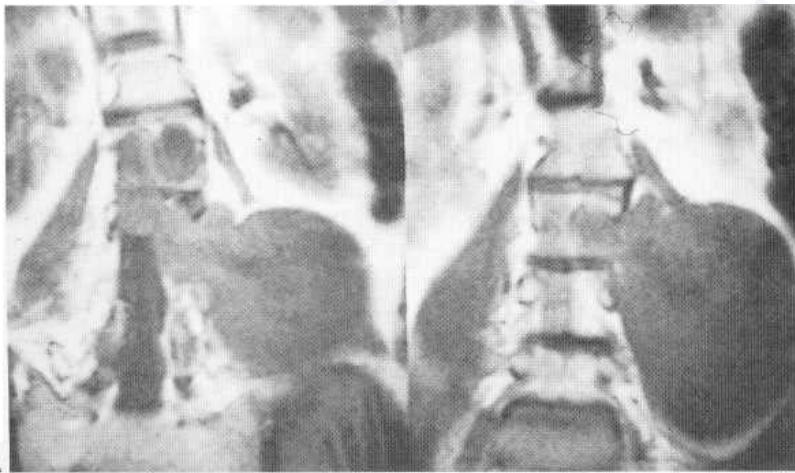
Neurofibroma demonstrated by coronal T₁-weighted (A) and axial (B) MR images. A typical dumb-bell tumour is shown with large extra-neural component. Note, however, there is extension into the exit foramen and other intrathecal abnormalities.
